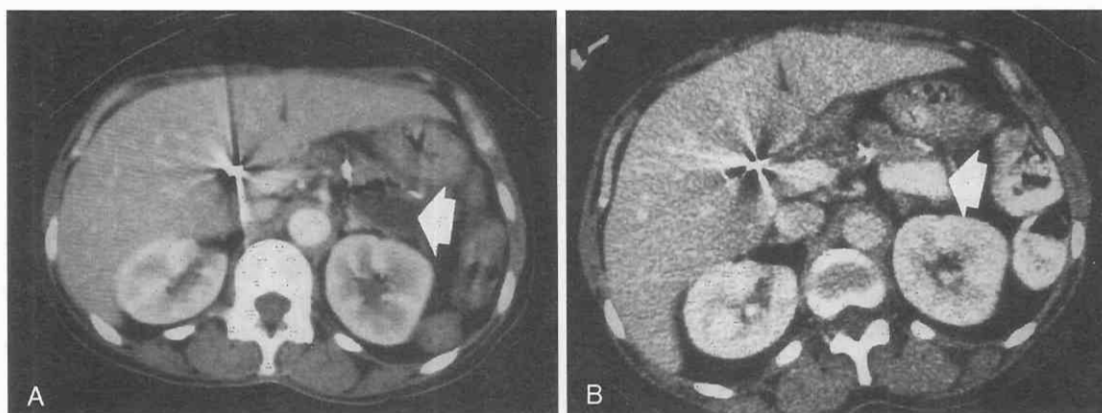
A, Appropriate surgery for pseudocysts is gastrocystotomy. CT scan shows fluid-filled and air-filled cavity (arrow) behind the stomach. B, Subsequent scan shows contrast material (arrow) filling the cyst cavity, indicating the nature of the cavity and communication with the stomach. Note the high-density suture line between the stomach and cyst.
